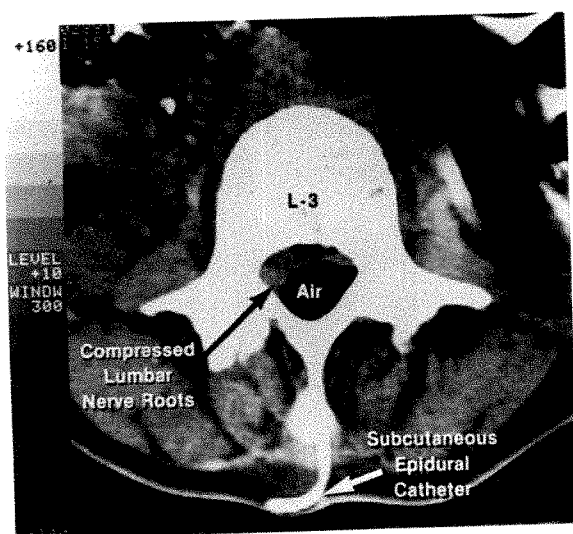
Cross-sectional CT scan at L₃ vertebral body demonstrating significant compression of thecal sac.
